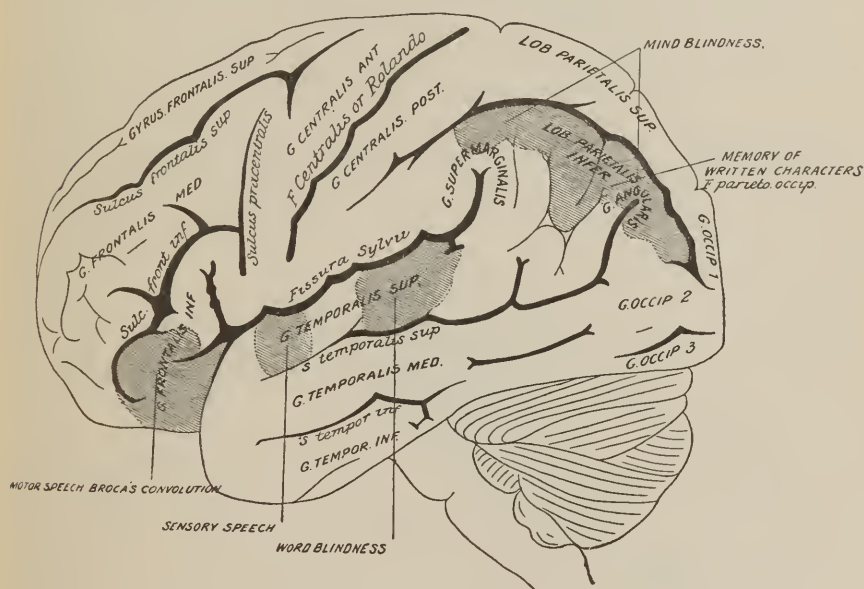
LATERAL ASPECT OF THE BRAIN.—(After Ecker, modified.)
